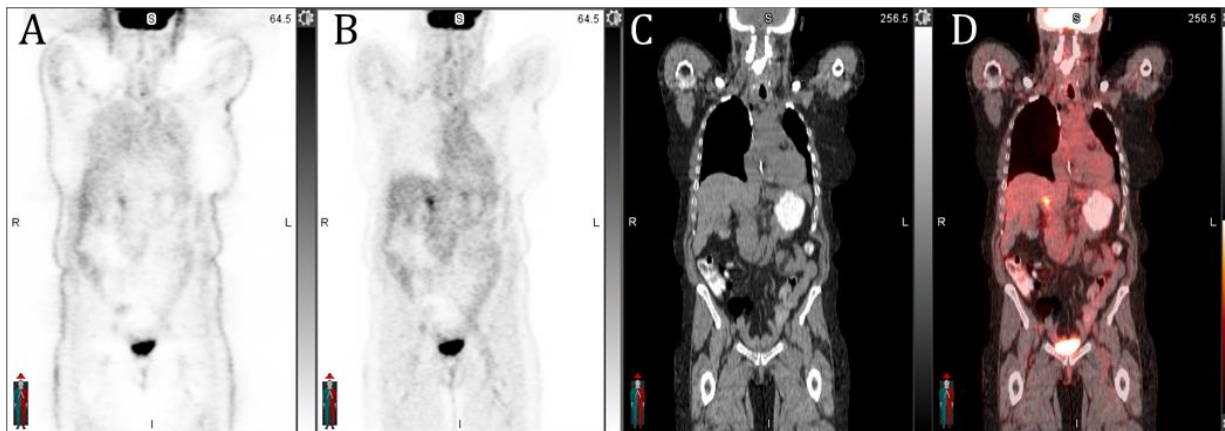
Effect of attenuation correction in PET imaging. A) Non-attenuation-corrected (NAC) PET image, B) Attenuation-corrected (AC) image using C) CT image acquired with the PET/CT. D) A fused attenuation-corrected and CT image together.
